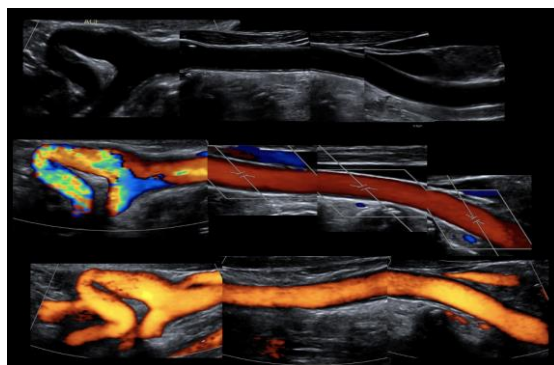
Carotid artery. B Mode, Color Doppler and Power Doppler. After the bifurcation, an internal carotid artery (ICA) with two angulations is observed, the first of 30° (Kinking) and the second of 45°. In the first portion, there is a slight decrease in the caliber of the vessel.
